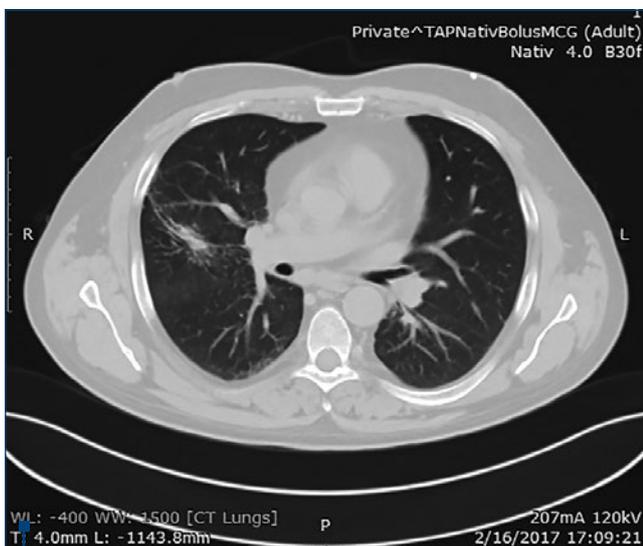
and 1B. Axial high-resolution CT scan (parenchymal window) reveals bilateral micronodular pulmonary opacities and significant spleen enlargement (abdominal window)
